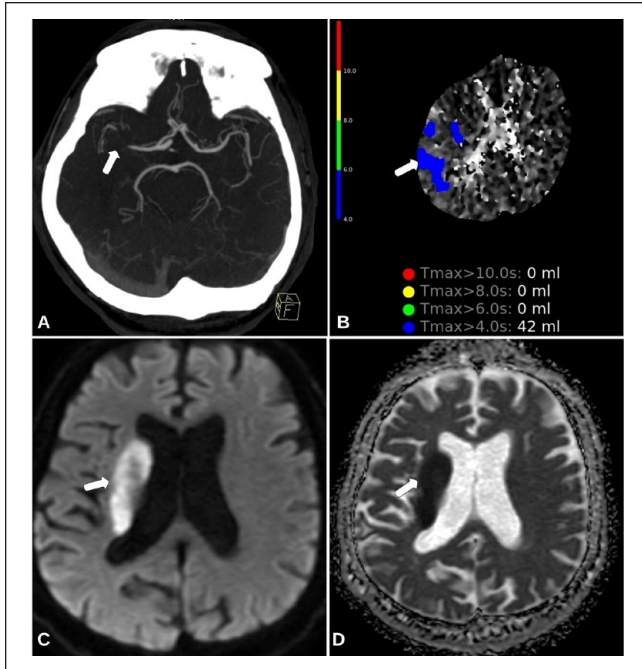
(A) CTA of the head depicting the occlusion (arrow) of the M1 segment of the right MCA. (B) CT perfusion imaging with a 42-mL salvageable penumbra (arrow) within the distribution of the right MCA territory. (C) Diffusion-weighted imaging (DWI) sequence depicting an acute infarction of the right basal ganglia (arrow) (D) correlated with the apparent diffusion coefficient (ADC).
